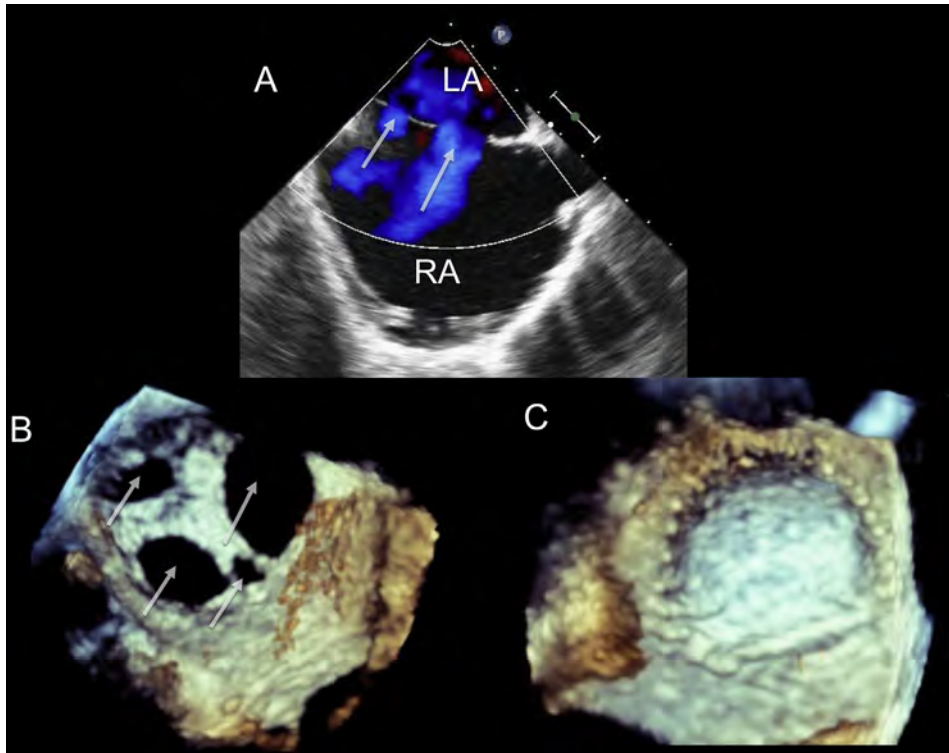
Three-dimensional TEE of multiple secundum ASDs (*white arrows*) resulting in a “Swiss cheese” configuration. (A) Bicaval view demonstrating at least two discrete ASDs with left to right color Doppler flow. (B) En face zoom acquisition from RA perspective demonstrating four discrete ASDs. (C) Zoom acquisition after minimally invasive surgical repair with a single pericardial patch. See also [Videos 6 and 7](#).
